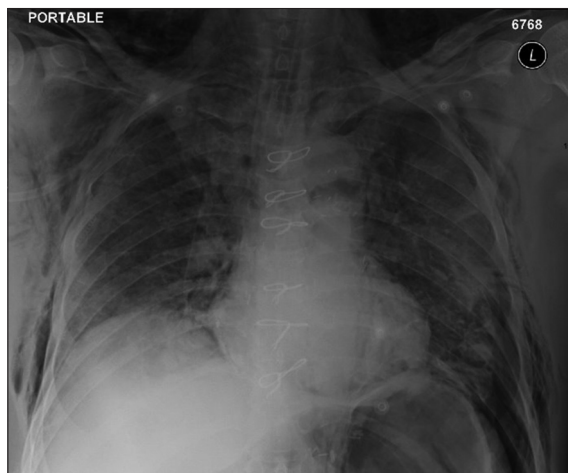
Chest X-ray of bilateral diffuse airspace opacities with bilateral lower zone atelectasis and bilateral subcutaneous emphysema
